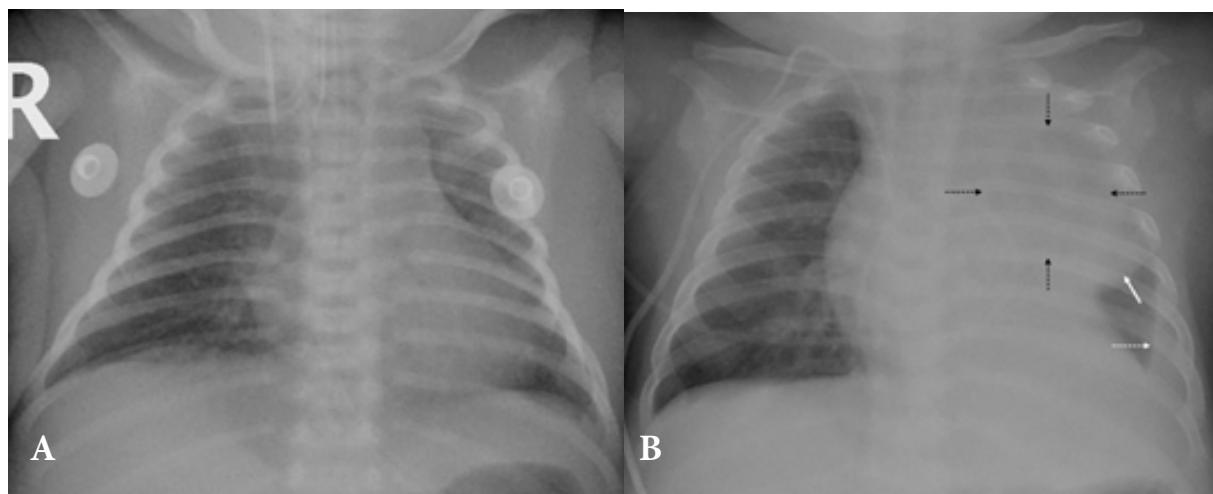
The chest radiograph of the 11-day old (A) from the first admission showed a normal cardiac size, small thymic shadow, and clear lungs. The chest radiograph on the second admission at the age of 4 months (B) showed a widened left side of the mediastinum reaching the lateral chest wall with an inferior bulging contour (white arrow). There was partial atelectasis of the left upper lobe with a small area of aerated lungs (black dashed arrows) superimposed on the lesion. There was the left pleural effusion (white dashed arrow) causing obliteration of the left hemidiaphragm and the left costophrenic angle.
